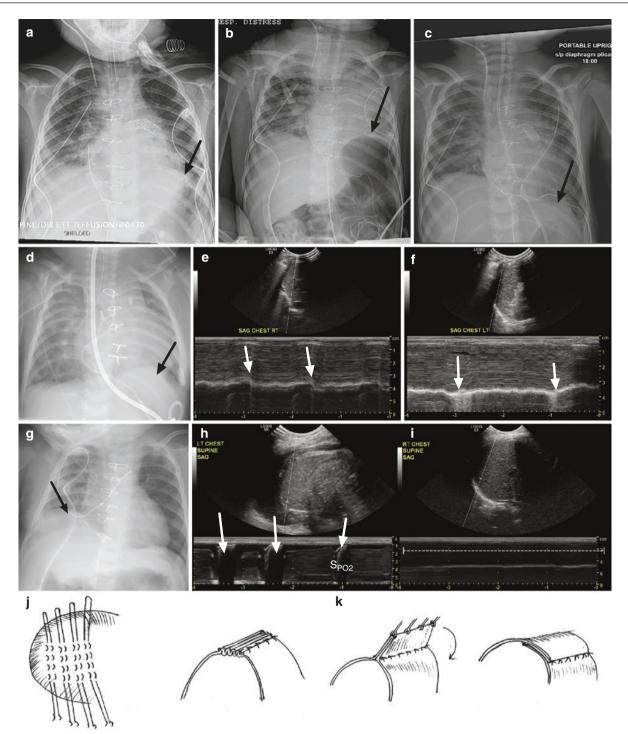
(a–c) Chest X-rays of a patients with left hemidiaphragm paralysis after Fontan operation: (b) compared with chest X-ray during intubation (a), elevation of the left hemidiaphragm (arrow) was noted after extubation with segmental atelectasis of left lung; (c) Chest X-ray after diaphragmatic plication, demonstrated improved left lung aeration, patient was immediately extubated in the operation room after plication. (d–f) A 1-month-old baby with left hemidiaphragm paralysis: (d) Chest X-ray demonstrated the elevation of left diaphragm (arrow), (e) M-mode of right diaphragm showed the diaphragm moved toward the transducer during inspiration (white arrow). (f) M-mode of left diaphragm showed paradoxical movement with diaphragm moved away
